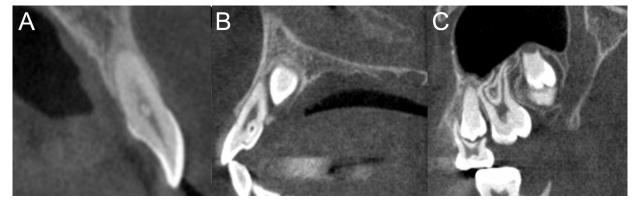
In the cross-sectional cone beam computed tomography (CBCT) images. (A) Pulp calcification is observed in tooth number 21. (B) Dens in dente is observed in tooth number 22. (C) The mesiobuccal root of tooth number 26 shows dilaceration.
